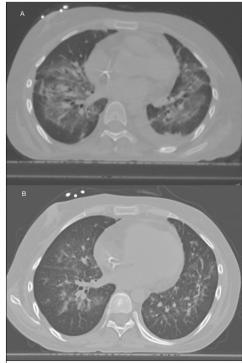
Chest CT images of patient D. (a) Diffuse bilateral ground-glass opacity and unilateral pleural effusion (b) lesions regressed significantly; pleural effusion absorbed.
